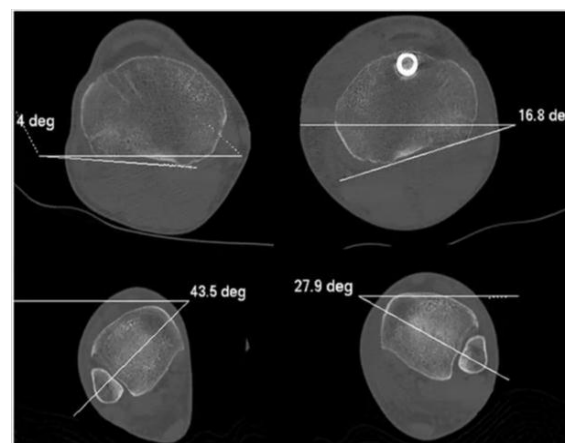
CT-based assessment of tibial rotational torsion. Proximal slices reference the dorsal aspect of the tibial plateau, while distal slices reference the tibiotalar joint. The difference between the injured and uninjured limbs defines the degree of rotational malalignment.
